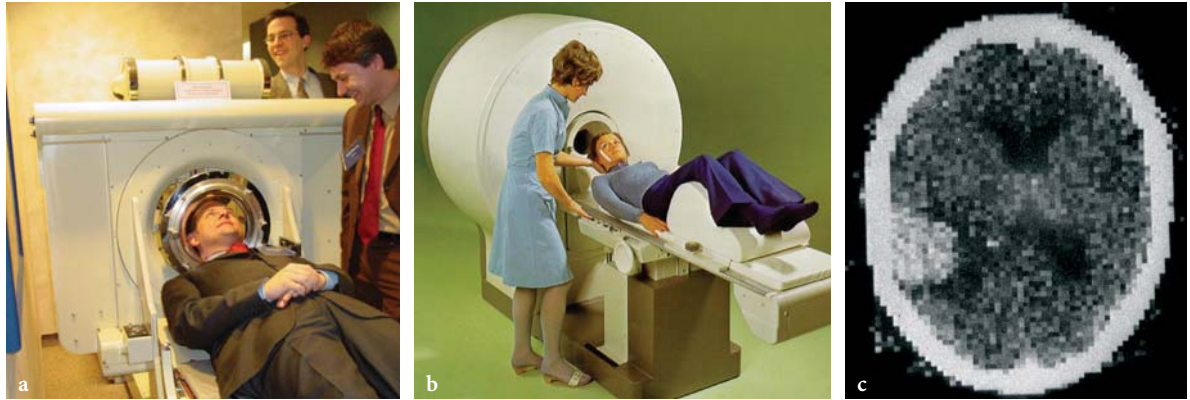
The first clinical CT scanners were introduced in 1972. a One of the earliest scanners, constructed by G. Hounsfield, can still be seen at the Mayo Clinic in Rochester, Minnesota (USA). b, c The first commercial CT scanners dedicated to brain imaging (e.g., Siemens Siretom, 1974) were able to acquire images of the brain with an image matrix of 64×64 pixels in 7 min scan time per slice
